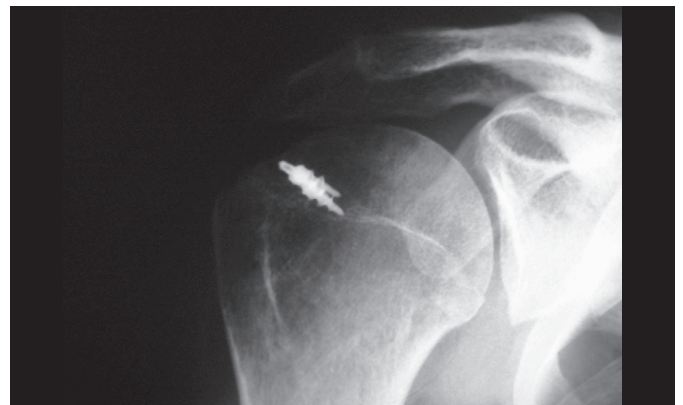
Simple X-ray of the shoulder in anteroposterior position demonstrating postoperative condition with adequate positioning of the anchors.
